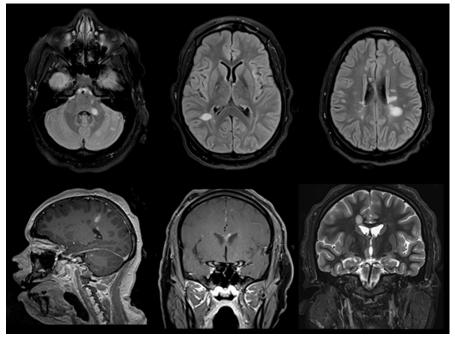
Axial FLAIR (*top row*) and coronal FLAIR (*bottom row, right*) images from a patient with confirmed POMS show multiple ovoid, hyperintense lesions within the white matter. On the contrast-enhanced sequence (*bottom row*), several lesions show ill-defined contrast enhancement.
